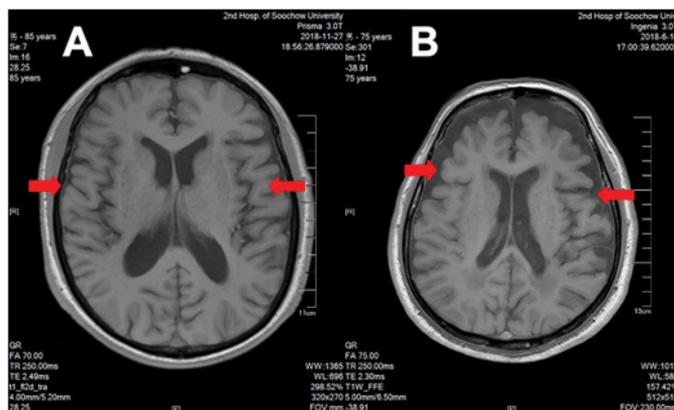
A. Cranial MRI of Patient 1 showed that multiple intracerebral infarction with the formation of partial softening lesions and senile brain atrophy; B. Cranial MRI of Patient 2 showed that multiple intracerebral infarction with the formation of partial softening foci, changes in deep cerebral white matter ischemia foci, and brain atrophy.
